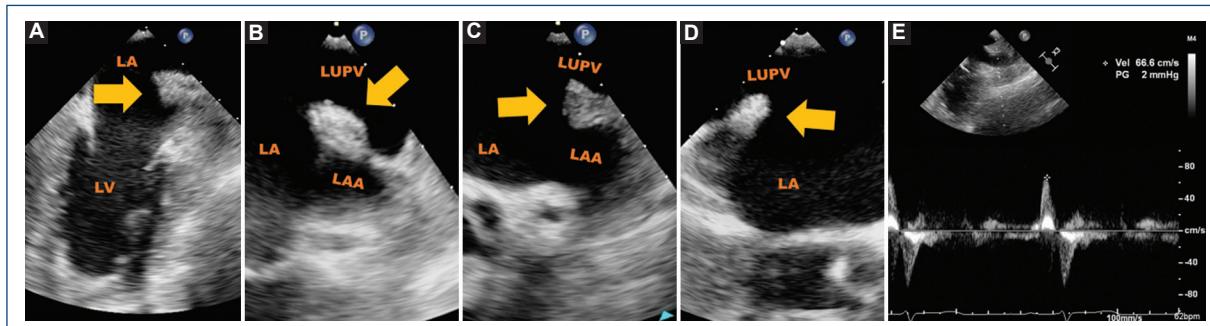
Transesophageal echocardiogram showing Coumadin ridge (yellow arrow): A: mid-esophageal view at 45°, B and C: mid-esophageal view at 60° and 64° respectively, zoom-mode acquisition of the left atrial appendage, D: mid-esophageal view at 180°, E: left atrial appendage with peak emptying velocity of 66 cm/s. LA: left atrium; LAA: left atrial appendage; LV: left ventricle; LUPV: left upper pulmonary vein.
